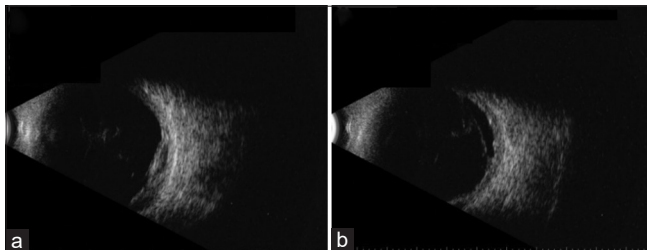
(a and b) Ultrasound images of oculus sinister post-transscleral cyclophotocoagulation showing vitreous opacities.
